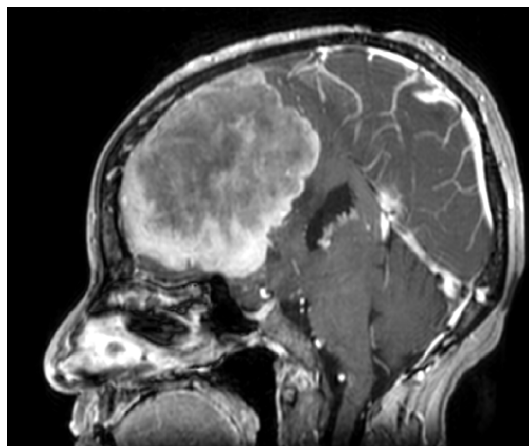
Sagittal T1 brain MRI with contrast showing huge extra-axial dural base enhance lesion with dural tail and compression on adjacent structures.
